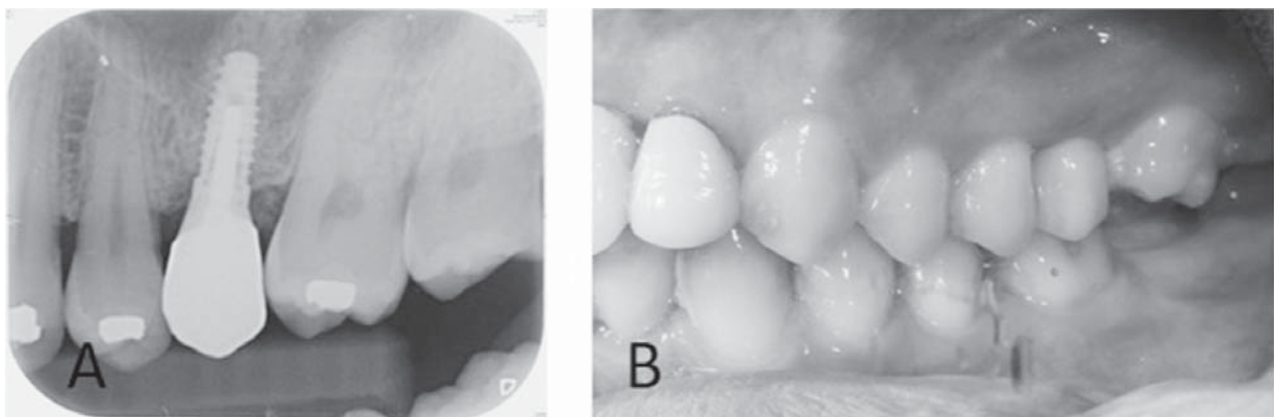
Prosthetic completion. A: Radiography; B: Clinical photography.
